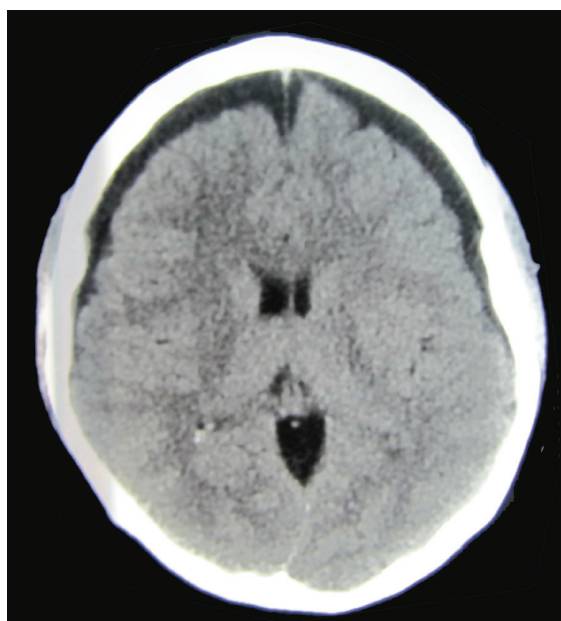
CT scan on 16th day after the car accident: subdural low density lesions in both frontal regions, the lesion on the left side being larger. The scan showed a decrease of gyral markings but no shifting of midline structures.
